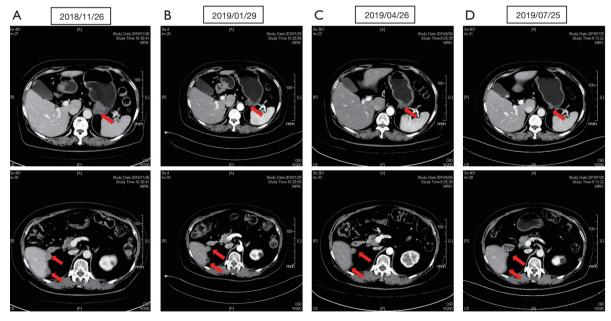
Contrast-enhanced CT images of the abdomen showing nodules and a mass inside the left side of the greater omentum and between the stomach and abdominal aorta. (A) Nodule with a diameter of about 3.5 cm with inhomogeneous reinforcement seen in contrast-enhanced CT; (B) nodule with a diameter of about 2.4 cm not obvious in contrast-enhanced CT; (C) nodule with a diameter of about 1.8 cm not obvious in contrast-enhanced CT; (D) nodule with a diameter of about 1.5 cm with slight reinforcement seen in contrast-enhanced CT. Two small nodules appeared outside the liver outline in the capsule of the right posterior lobe of the liver. CT, computed tomography; A, anterior; R, right; L, left; P, posterior.
